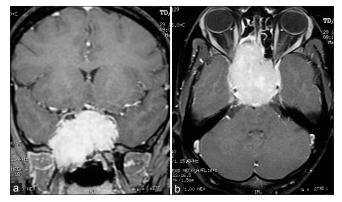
Gadolinium-enhanced magnetic resonance imaging (a) coronal view, (b) axial view showing tumor extensions
